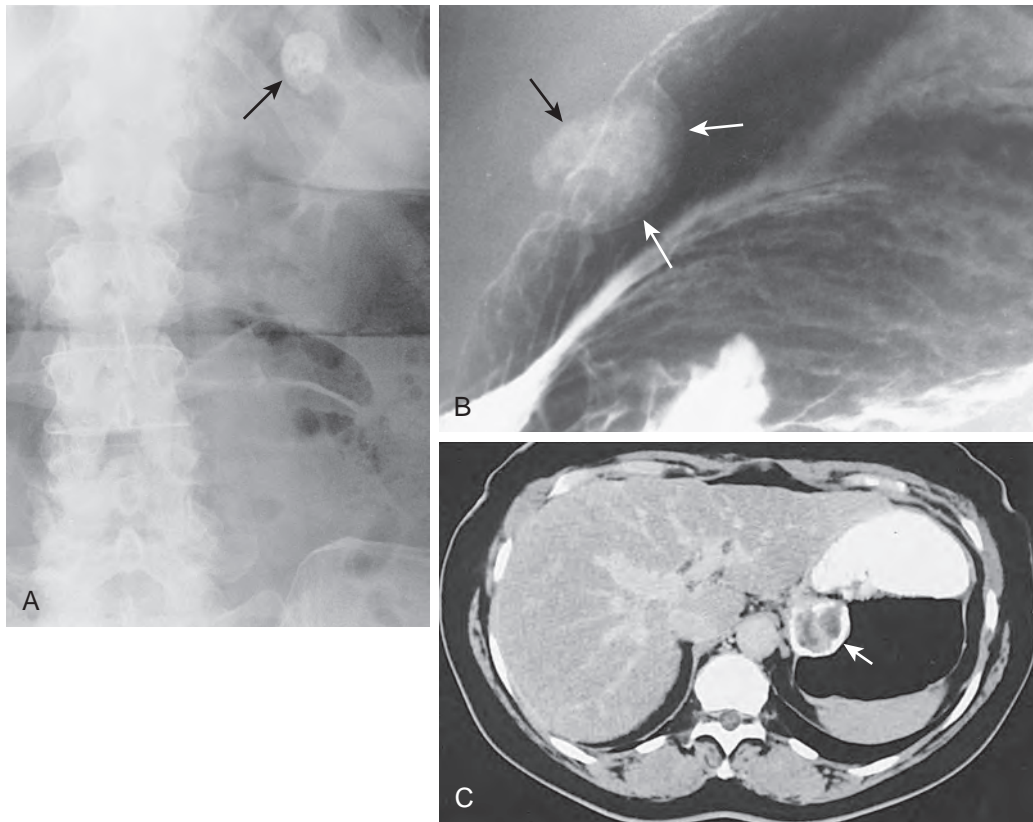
Benign GISTs with calcification. A. Close-up view of an abdominal radiograph reveals a dense clump of calcification (arrow) in the left upper quadrant. B. Barium study shows that this calcification (black arrow) is located within a discrete submucosal mass (white arrows) in the stomach. At surgery, the lesion was found to be a benign GIST. C. In another patient, a peripherally calcified benign gastric GIST (arrow) is shown on a CT scan. (C courtesy Alec J. Megibow, MD, New York.)
